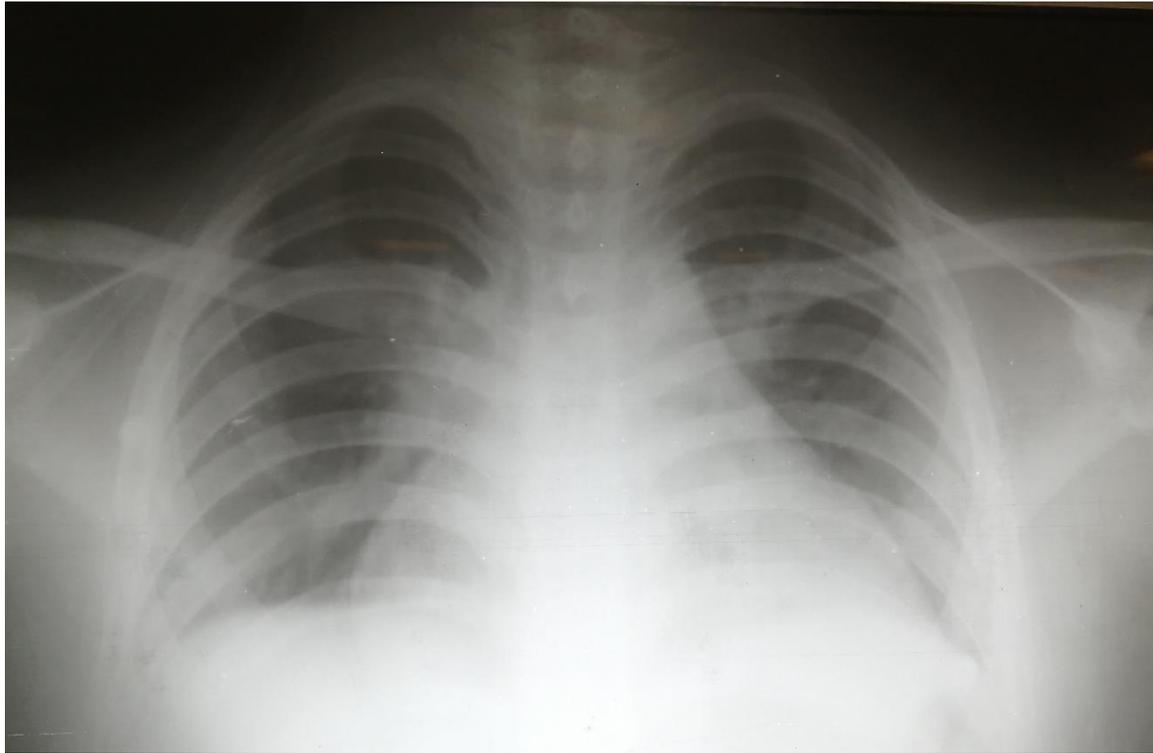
Chest radiograph showing cardiomegaly
